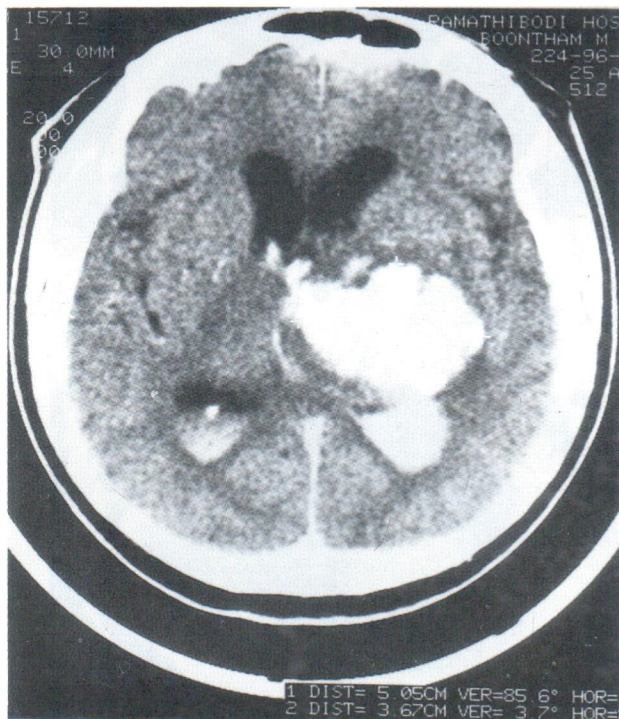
CT shows large hematoma in left thalamus and blood in the occipital horns and third ventricle
